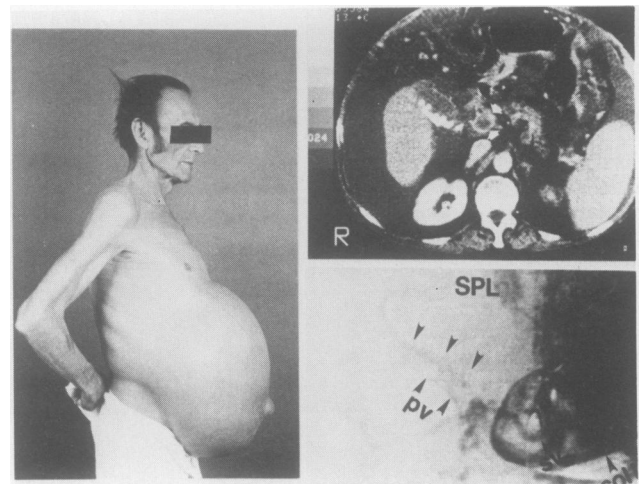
Initial presentation of cirrhosis (Table 1, patient 10) with prominent ascites (left). One year after insertion of a LeVeen shunt, and 2 weeks after umbilical herniorrhaphy ascites recurred and became massive. Computed tomography (CT) with contrast enhancement (upper right) demonstrated only the outer wall of the portal vein consistent with portal vein thrombosis (white arrows). This finding was corroborated on digital-subtraction angiography (lower right), displaying filling defects in the portal vein and absence of venous arborization within the liver. SPL, splenic arterial injection; pv, portal vein; SV, splenic vein; and coll, venous collateral.
